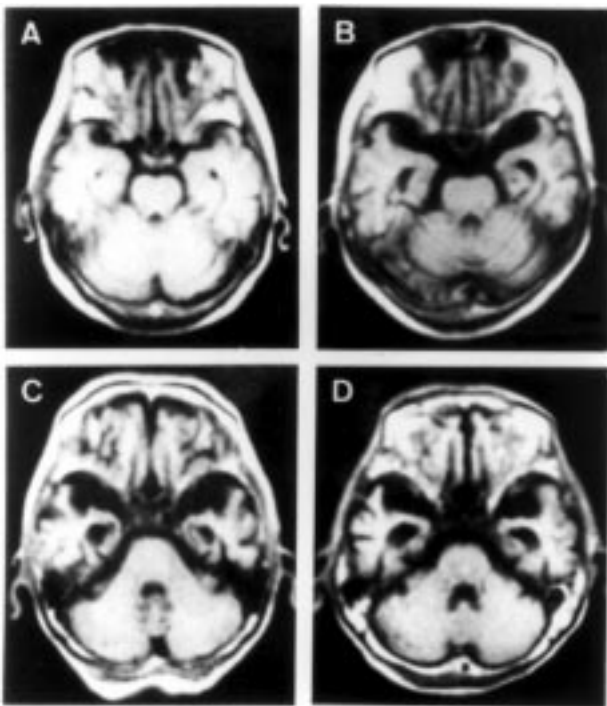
Findings of MRI at the level of the pons. No atrophy was observed in the inferior temporal lobe of the control subject (A). Patients with $\epsilon 3/\epsilon 3$ (B), $\epsilon 3/\epsilon 4$ (C) and $\epsilon 4/\epsilon 4$ (D) genotypes showed mild, moderate or severe atrophy, respectively.
